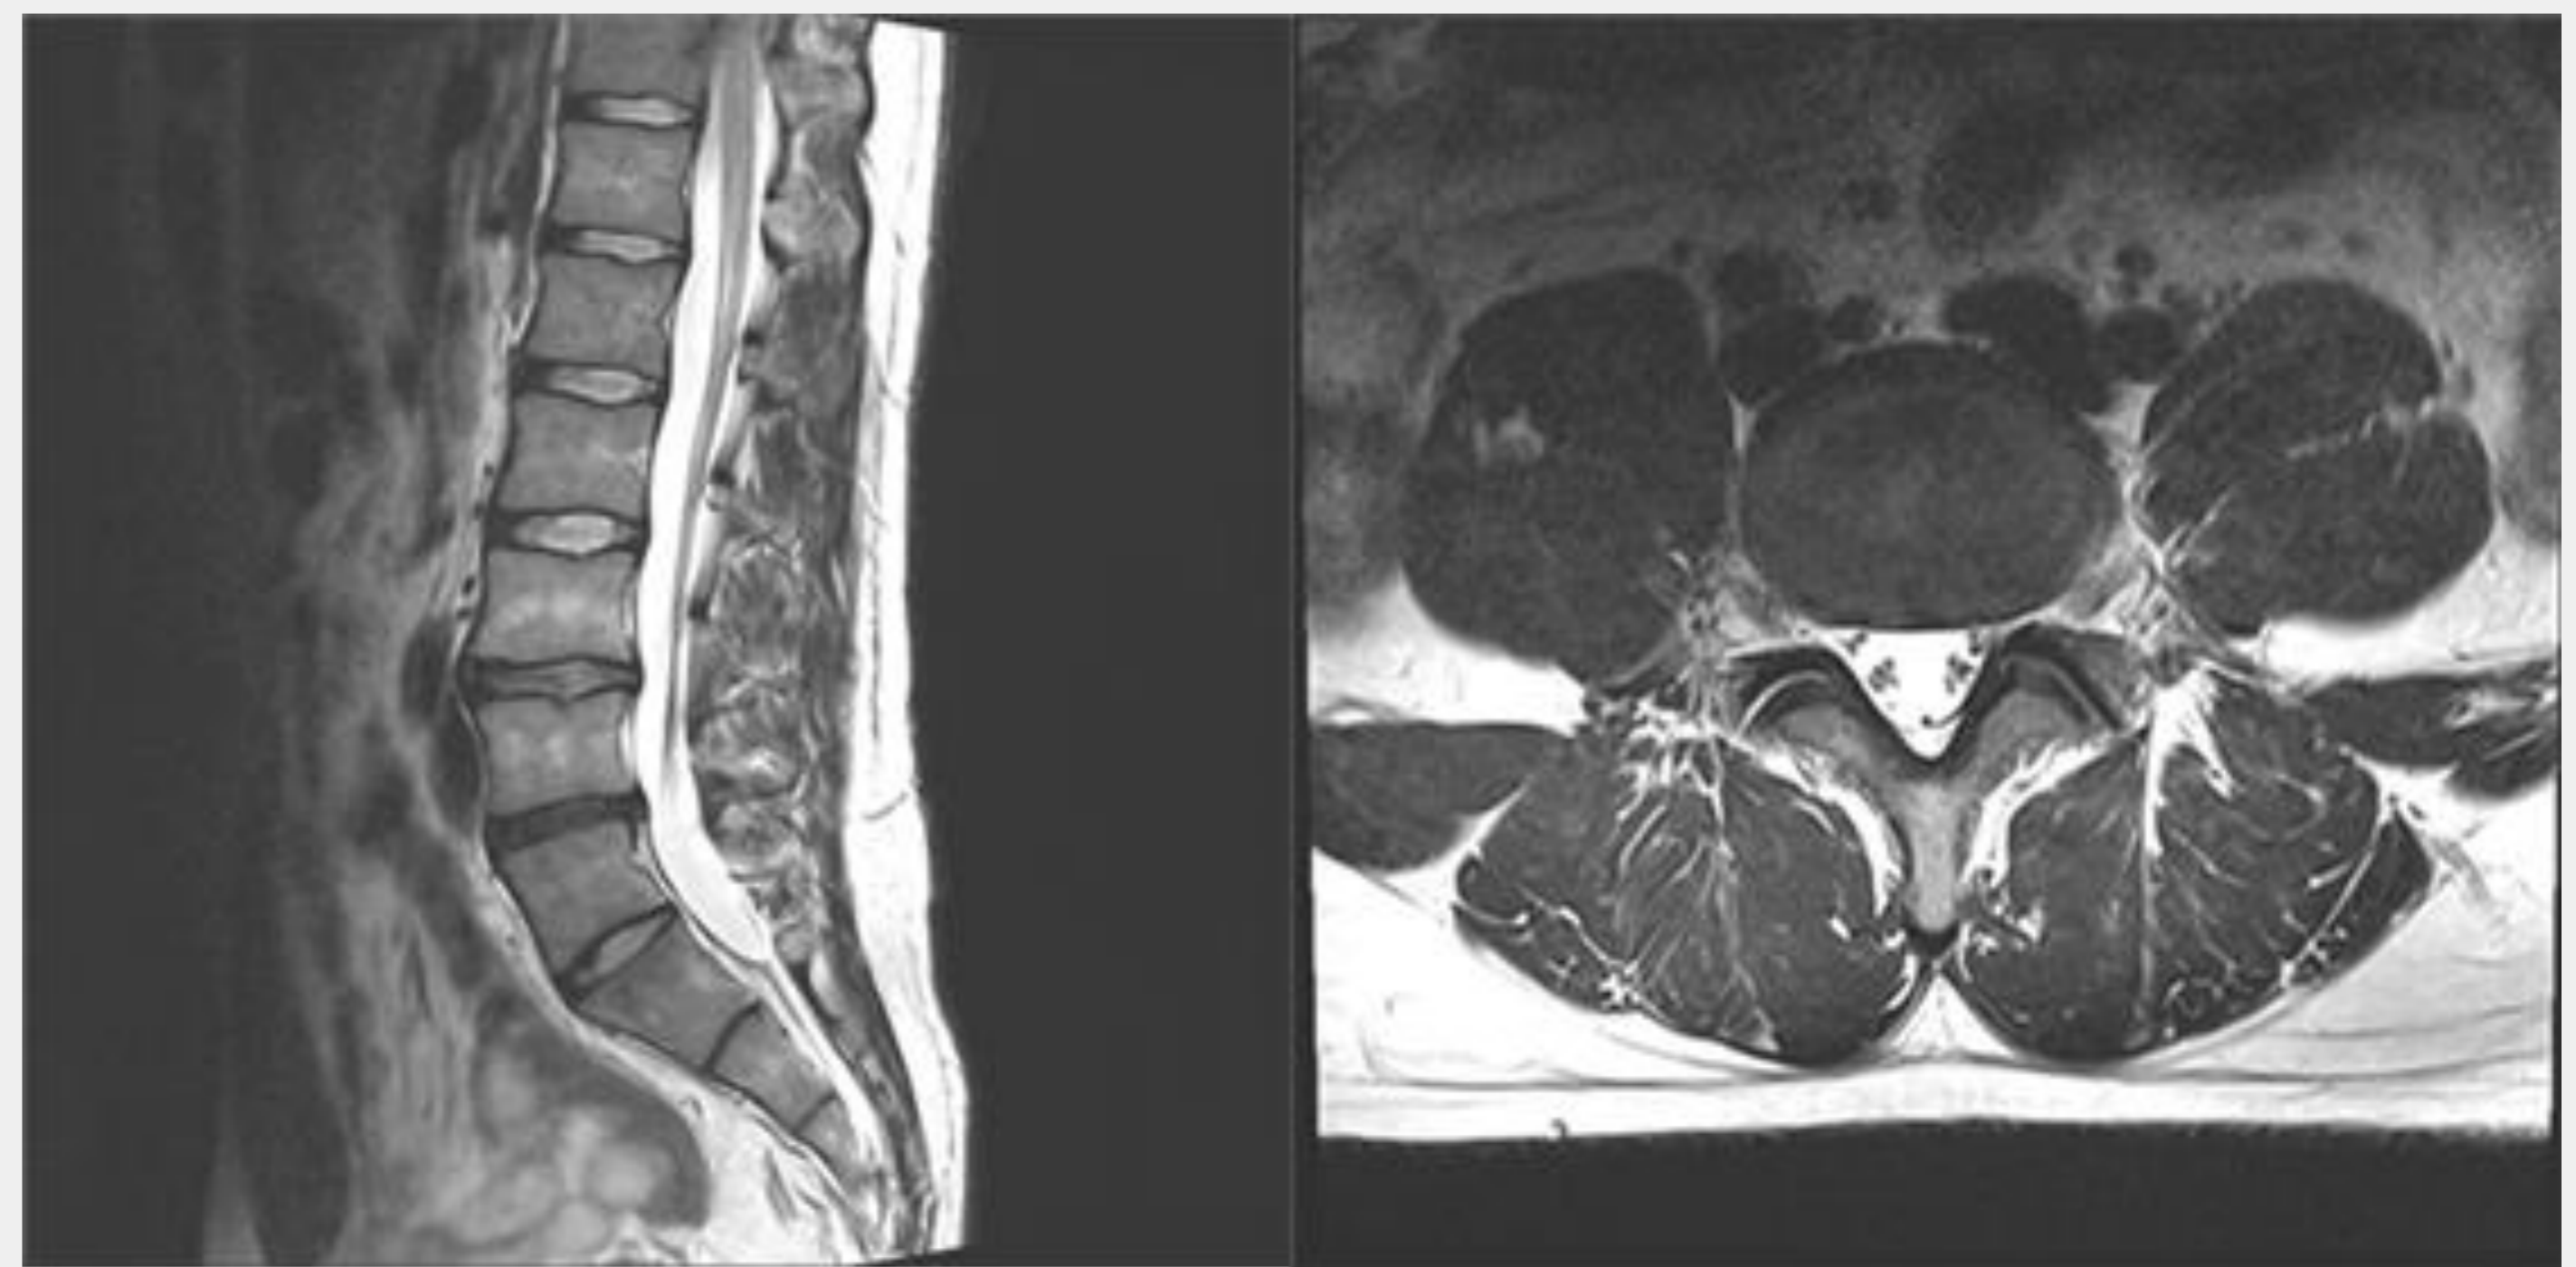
Lumbar spine magnetic resonance imaging (MRI) demonstrated no definite evidence of nerve root compression or radiculopathy
